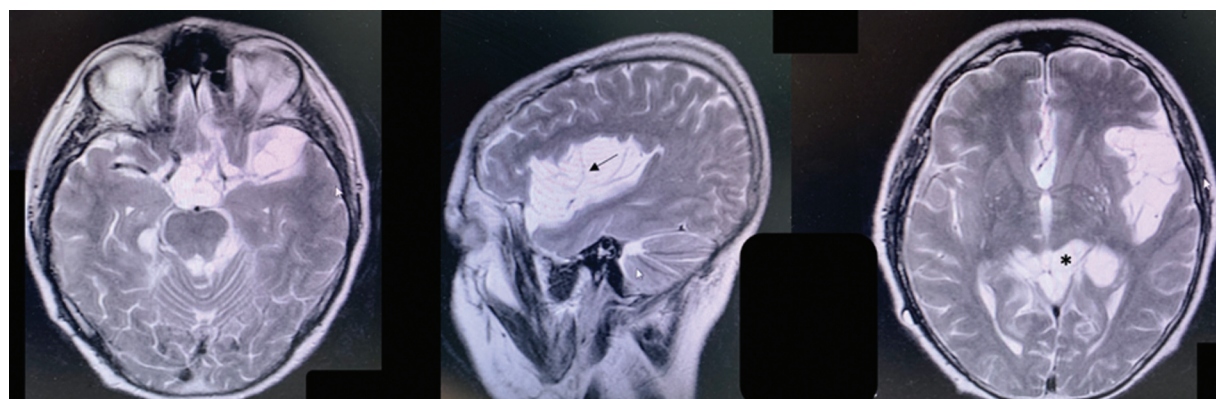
Axial T2-weighted magnetic resonance imaging (left and right), sagittal (middle), revealing multiple loculated cystic lesions in the territory of the Sylvian fissure (arrow) and in the quadrigeminal cistern (asterisk).
